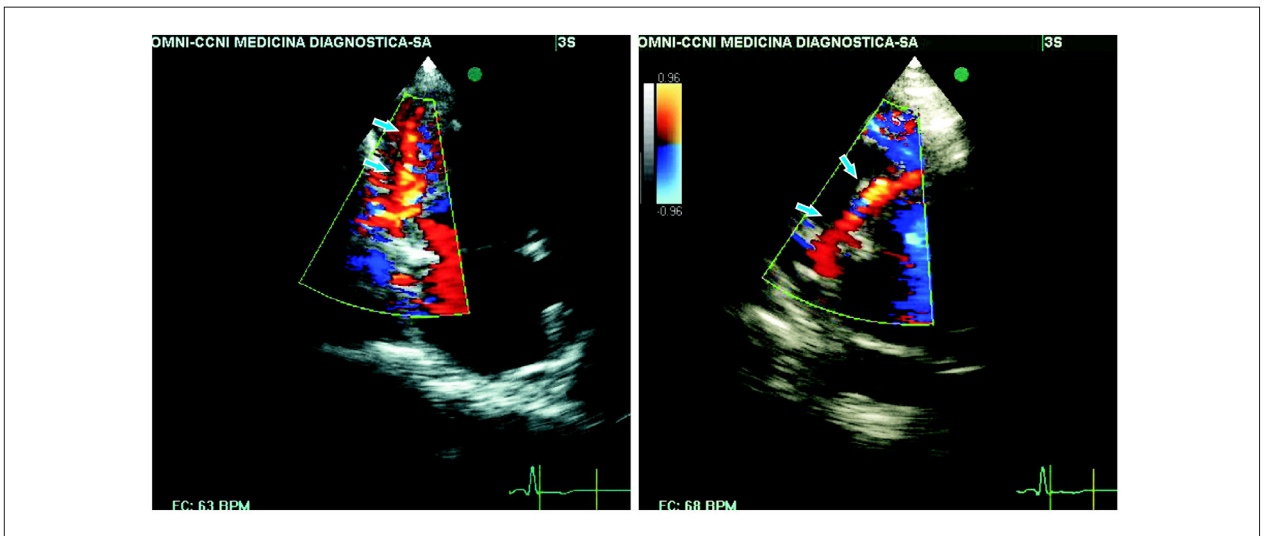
Transthoracic echocardiogram with dilated coronary arteries and hyperflow (arrows).
